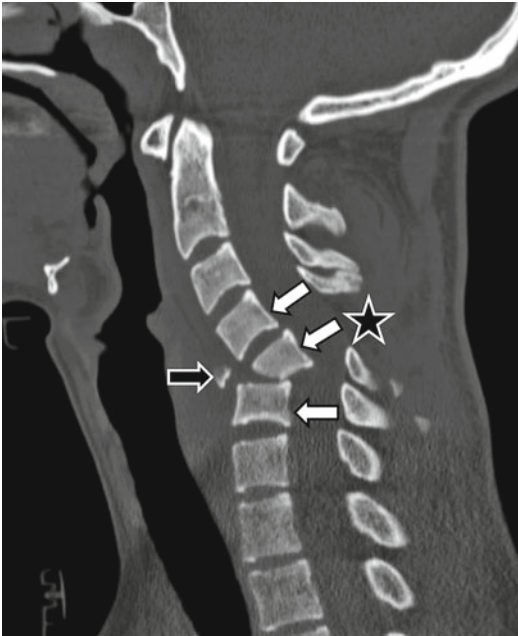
Sagittal reconstruction of a cervical spine CT in a 35-year-old male involved in a high-speed motor vehicle accident demonstrates focal kyphosis at C5 with a fracture fragment donated from the anterior inferior C5 vertebral body (*black arrows*). Note the complete disruption of the posterior longitudinal line (*white arrow*) and the marked splaying of the spinous processes (*star*)
